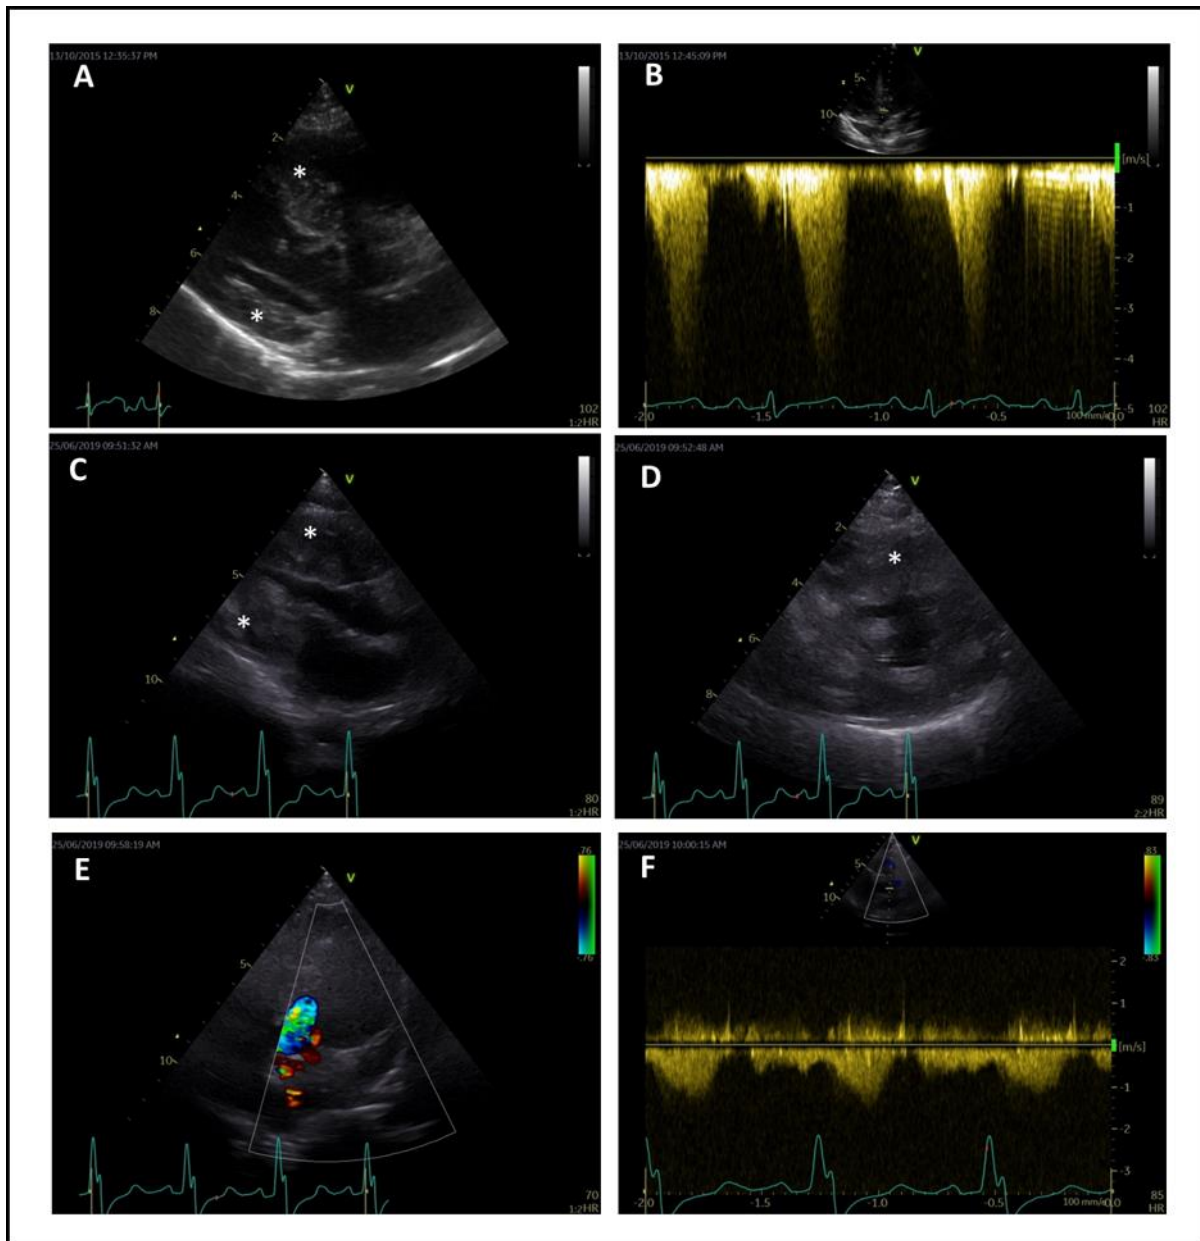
Echocardiographic images of patient 6, Related to Figure 1. Transthoracic echocardiographic imaging of patient 6 (Noonan syndrome, *RAF1*, female, 34 months of age) at the time of admission to the hospital for surgical left ventricular outflow tract resection (panel A and B), and at the time of follow-up (78 months of age, panel C, D, E and F). Depicted are the parasternal long axis view (panel A and C), parasternal short axis view (panel D), and the apical 5-chamber view (panel B and E) with color Doppler (panel E) and continuous wave (CW) Doppler (panel B and D) imaging. There is severe myocardial thickening (*), the peak gradient over the left ventricular outflow tract measures 92 mmHg before resection of the left ventricular outflow tract (panel B). There is no obstruction of the left ventricular outflow tract at the time of follow-up (panel F).
